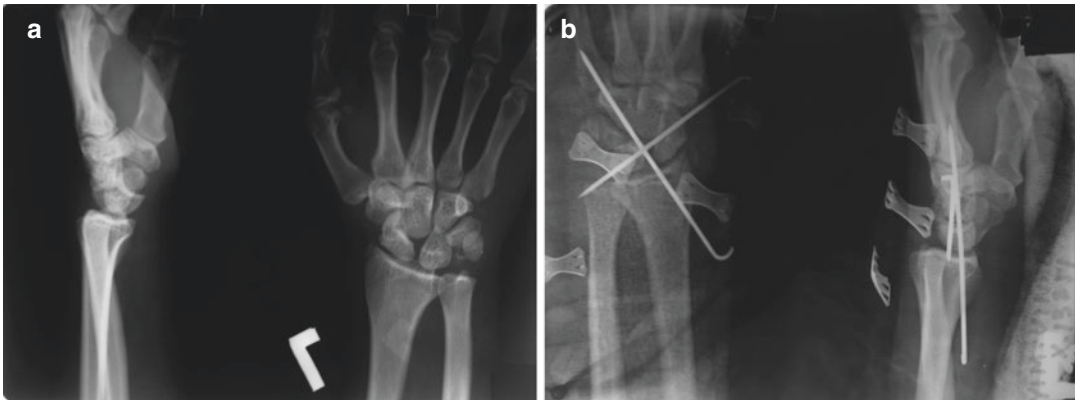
Perilunate dislocation (a) x-ray presentation (b) after closed reduction and crossed pinning. Scapholunate dissociation persists, but carpal alignment is restored
